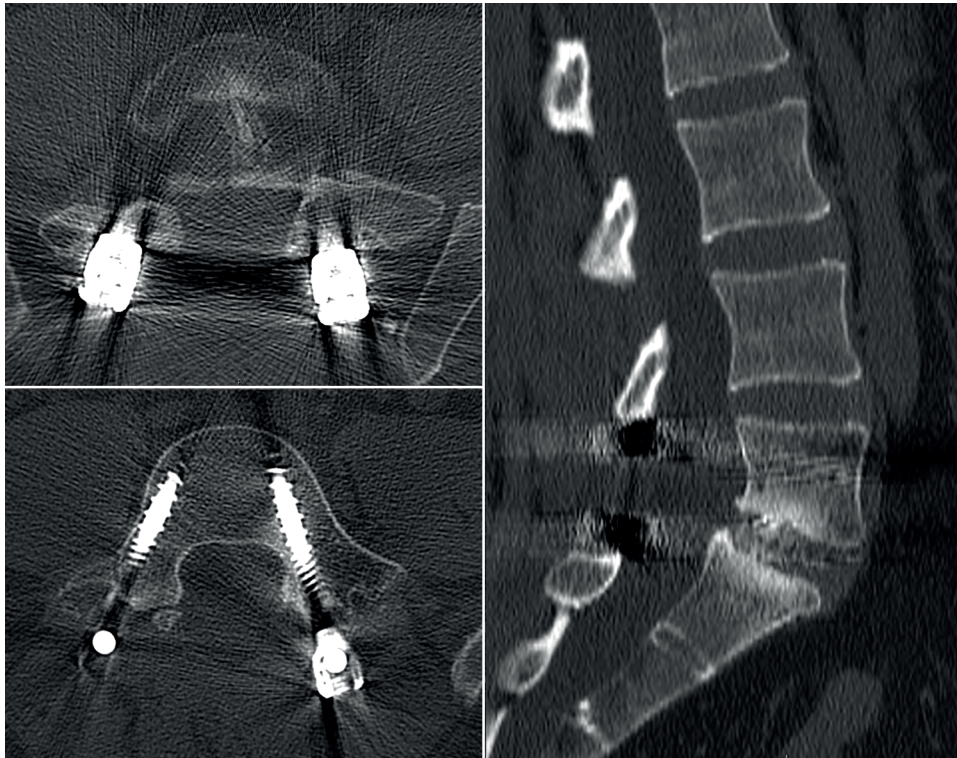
CT scan performed at 1-year follow-up shows the stability of the implant and TLIF fusion rate grade 1 according to Williams's criteria.
